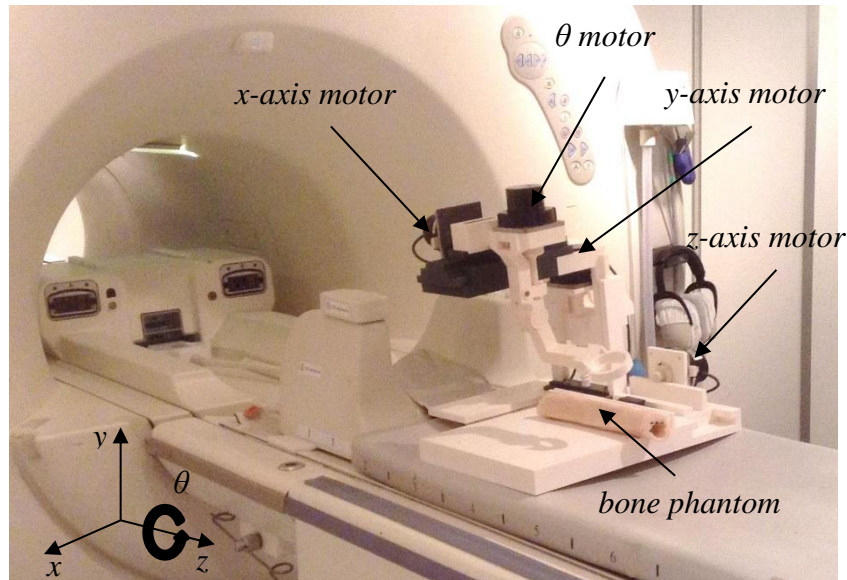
Setup of HIFU bone treatment positioning device on the MRI table with notations pointing the PUM motors that control motion in the xyz axes and θ rotation..
